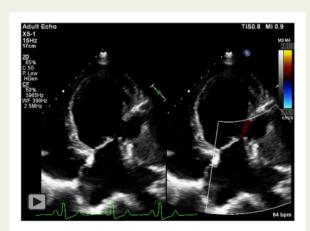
(A) Cardiac magnetic resonance bright blood image (frame from Cine SSFP sequence) in four-chamber view showing large aneurysm arising from the basal inferolateral wall of LV with large eccentric hypointense thrombus. (B) Corresponding late gadolinium-enhanced image showing enhancement of the thinned out aneurysmal wall with large internal non-enhancing thrombus. (C) Echocardiogram showing large submitral aneurysm (SA) (7.7 cm \times 6.6 cm) with wide neck and organized thrombus. (D) Colour Doppler across mitral valve (MV) showing moderate MR.
